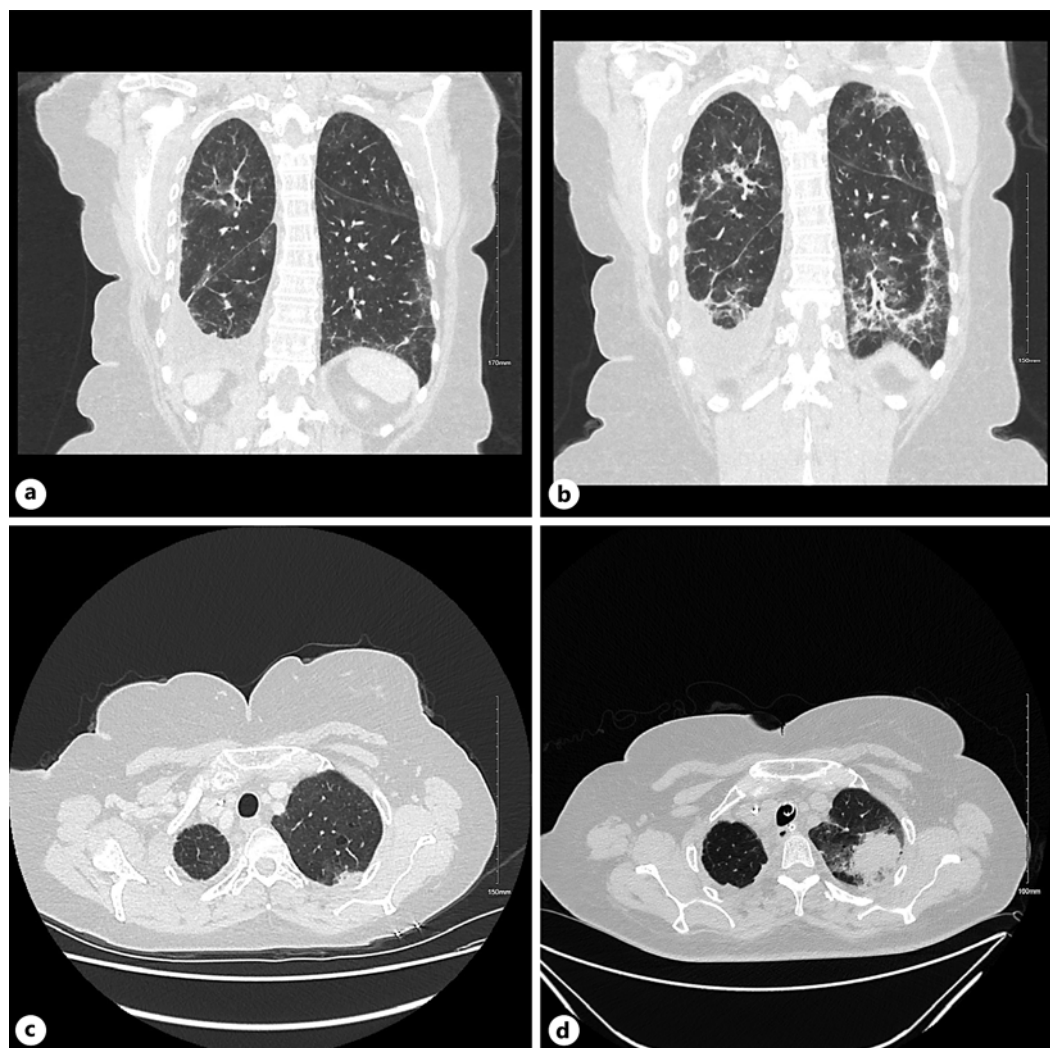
a January 2023: coronal CT with good cancer control on pembrolizumab. March 2023: evidence of pneumonitis on coronal scan (b), but no mass in the left upper lobe on axial imaging (c). d April 2023: new left upper lobe mass reflecting *Nocardia* infection.
